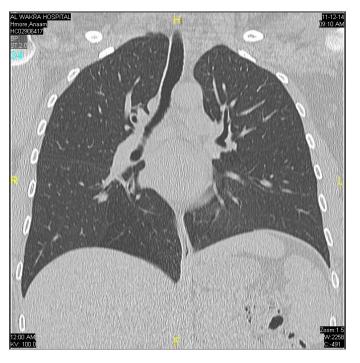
Low done non contrast CT chest done show no trace of any lung pathology and complete resolution of the pathology.
